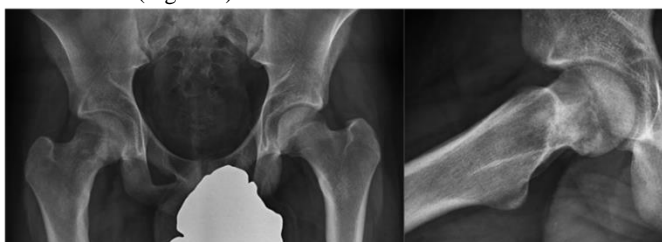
X-ray of the right femur showing a sclerotic lesion with continuous periosteal reaction at the level of the femoral neck.
